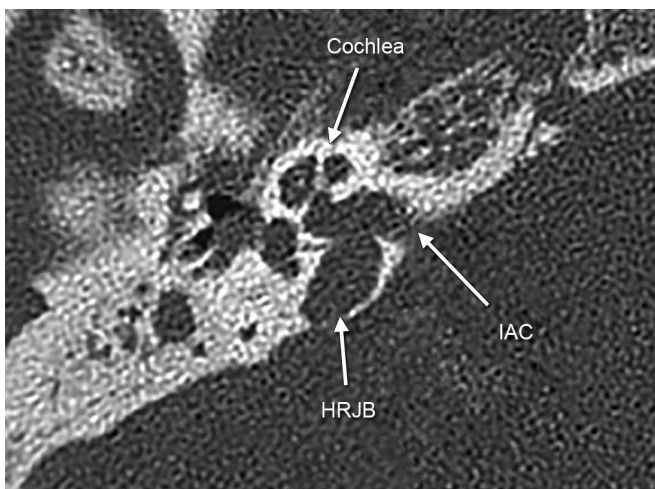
High-resolution computed tomography (HRCT) of the right ear showing a high-riding jugular bulb (HRJB) at the level of the internal auditory canal (IAC).
